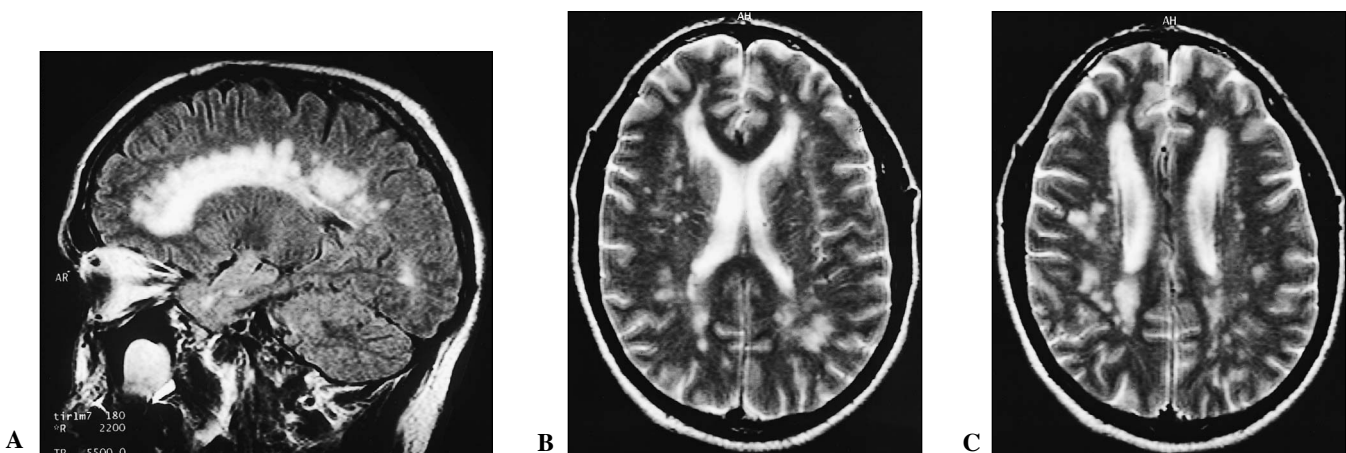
A-C, Sagittal FLAIR (A) and axial T2 (B and C) images in an asymptomatic male sibling reveal marked confluent signal hyperintensities in the periventricular white matter (A), and more patchy signal hyperintensities in the subcortical and deep white matter (B and C).
